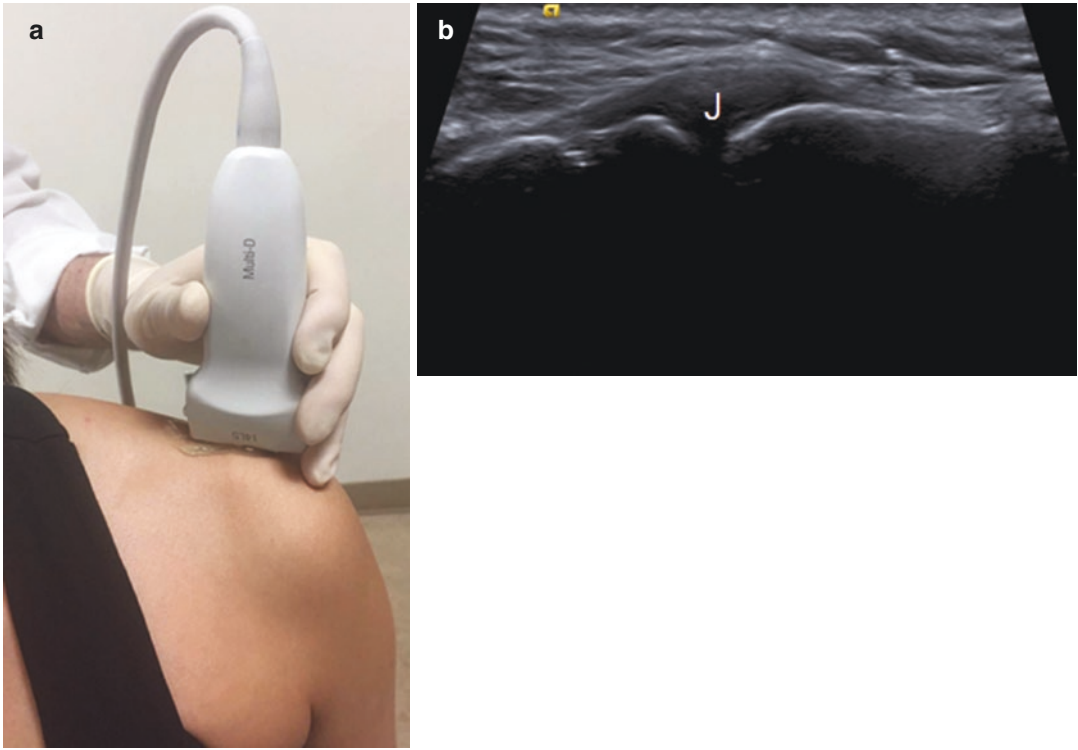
Acromioclavicular joint imaging—patient positioning (a); sonographic image (b); joint capsule (J)
